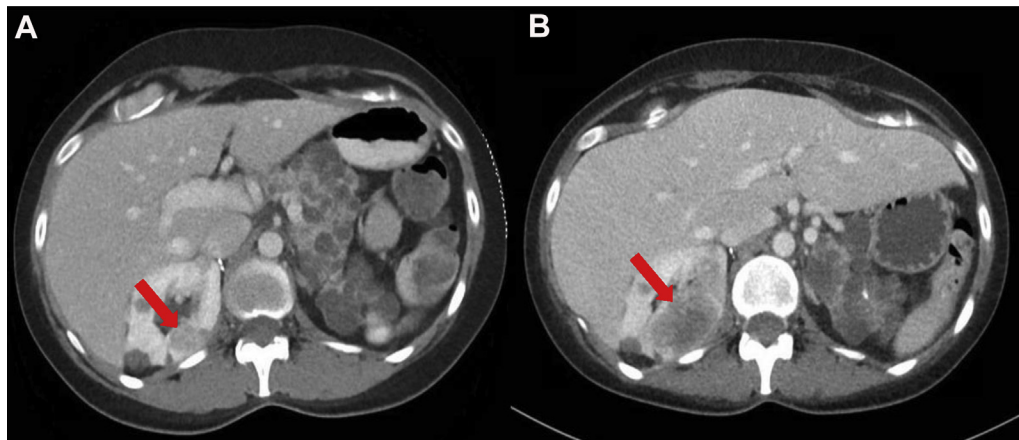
Preoperative axial computed tomography scans revealed a renal mass located in the right posterior upper pole that grew from approximately 2 cm (A) to 5 cm (B) in 5 months.
